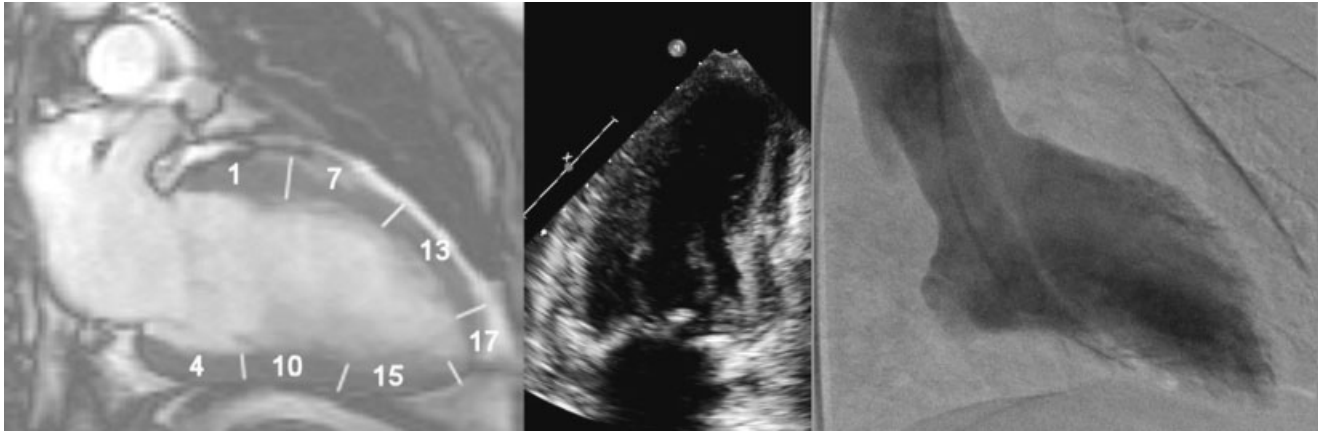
The left panel shows the vertical long axis image, with its segmental pattern, as obtained using magnetic resonance imaging. The middle panel shows
